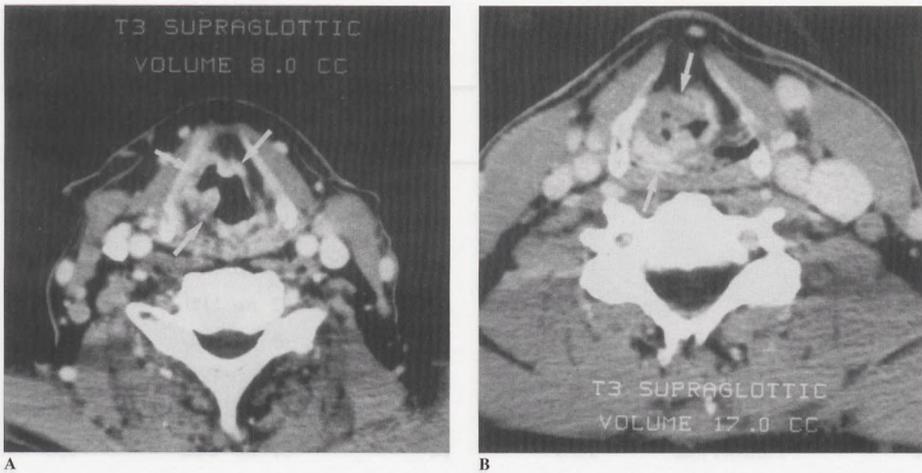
CT axial sections of two different patients with T3 supraglottic larynx carcinoma showing difference in tumor volume of > 100%. (A) Superficial semicircular tumor (straight arrows); total volume = 8.0 cm³. (B) Bulky tumor (straight arrows); total volume = 17.0 cm³.
